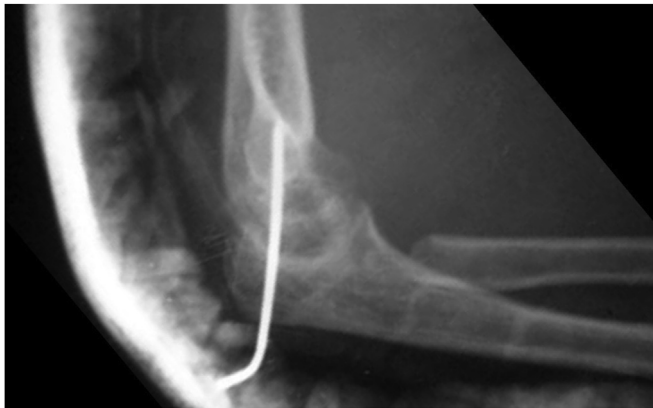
Lateral radiograph following ulnohumeral pinning and radial head excision, performed approximately five weeks postinjury after failed conservative treatment at an outside institution.
